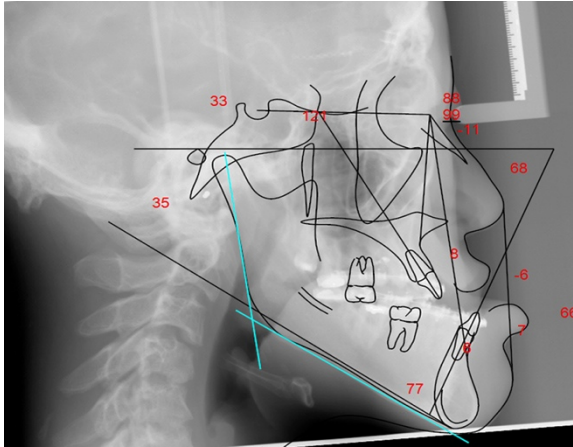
Pre-surgical progress; lateral cephalometric x-ray with tracing.
